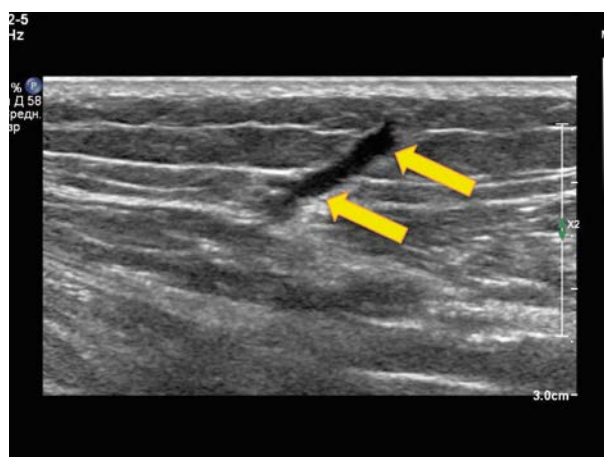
image of the perforant vessel (indicated by arrows) at the broadband range of the linear sensor 18-4 MHz in the mode of high-contrast seroscale sonography.
